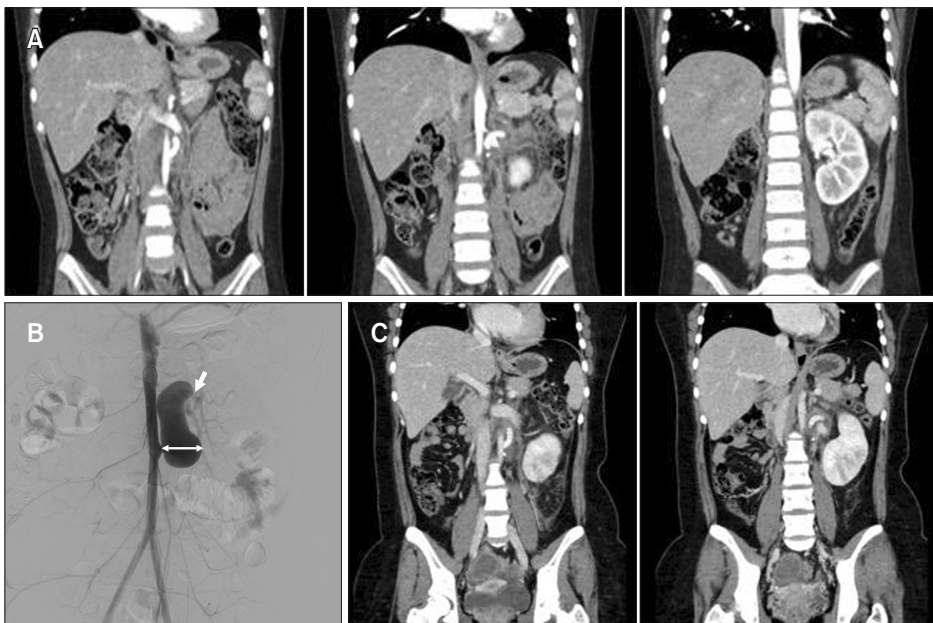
(A) Computed tomography (CT) showed the patent aorto-renal bypass graft without stenosis or aneurysm. (B) Angiography 2 years after surgery revealed aneurysmal dilatation (2.3 cm, two-way arrow) of the autologous vein graft. Arrow indicates distal anastomotic stenosis. (C) CT after endoaneurysmal graft replacement with expanded polytetrafluoroethylene graft showed patent graft.
